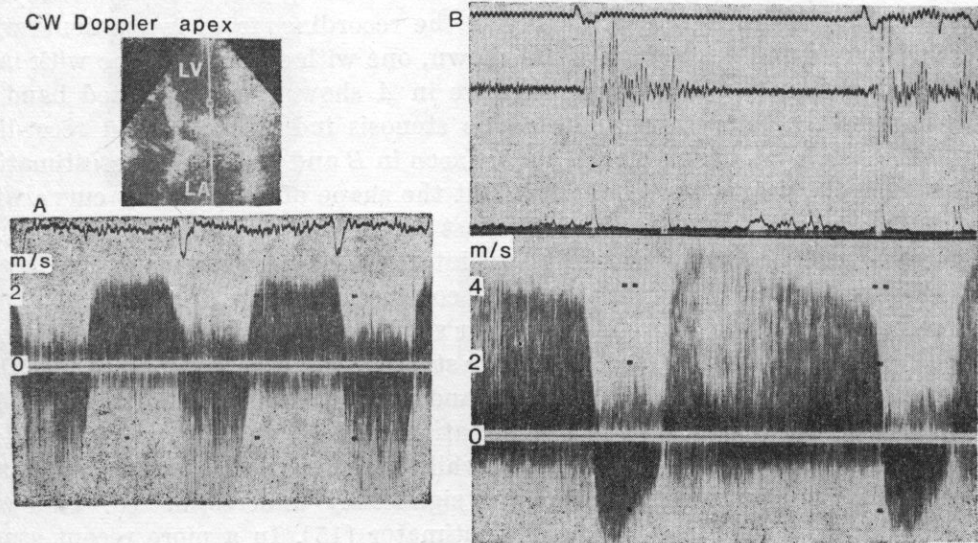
When recording with CW Doppler from the apex the high velocity through the mitral orifice is recorded toward the transducer in diastole and mitral regurgitation away from the transducer in systole. In sinus rhythm there is a second peak following atrial contraction (A). In the patient with atrial fibrillation (B) there is still a pressure difference between the left atrium and ventricle even in a long diastole, indicating significant obstruction. The calculated mean pressure drop in A is 22 mm Hg, in B it varies with diastolic length, early diastolic pressure difference is 25 mm Hg and at end diastole it is 2 and 13 mm Hg for the two beats shown. Regurgitation is seen to start at mitral valve closure and it continues past aortic closure, lasting until the mitral valve opens again
